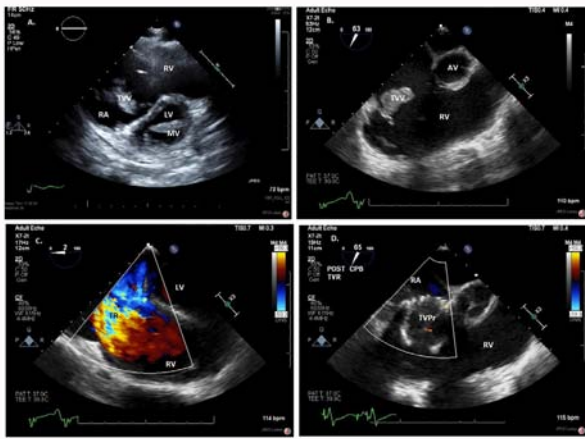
Panel A: Pre-operative transthoracic echocardiogram revealed dilated Right Ventricle (RV) and Right Atrium (RA) with large TV Vegetation (TVV). Left Ventricle (LV) and Mitral Valve (MV) were not affected. Panel B: Intra-operative trans-esophageal echocardiogram confirmed very large TV Vegetation (TVV) and dilated Right Ventricle (RV). Panel C: Severe TV Regurgitation (TR) was noted intraoperatively. Panel D: Infected TV was replaced with tissue Mosaic tricuspid valve prosthesis (TVPr) without a para valvular leak, regurgitation, or stenosis.
